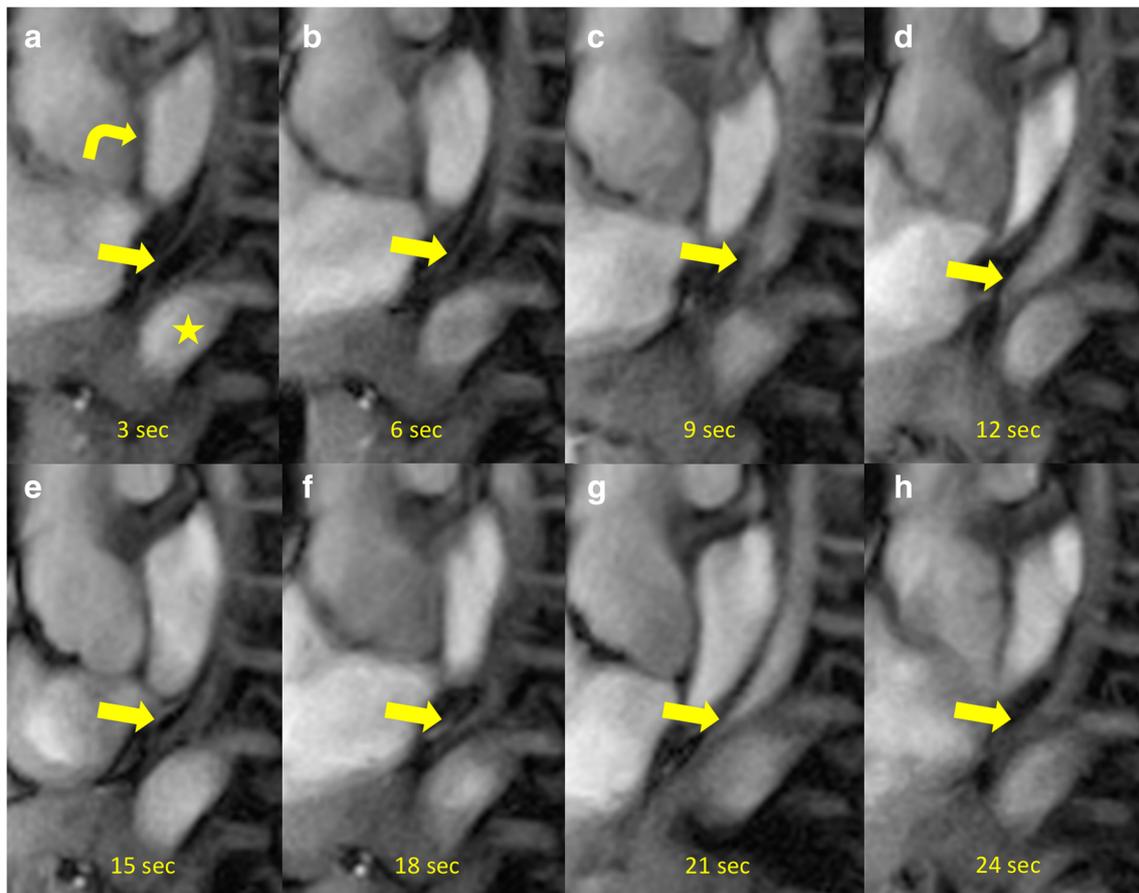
Real-time MRI of the gastroesophageal junction after fundoplication during bolus passage. Scan was performed at 25 fps. Representative individual images were selected showing bolus passage in sagittal planes. Delayed esophageal bolus transit and reduced propulsive peristalsis. Image a shows normal anatomy of the distal
